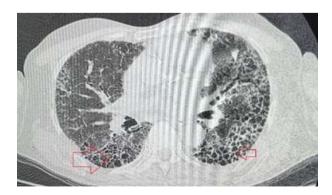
High resolution computed tomography showing UIP pattern (red arrows) of interstitial lung disease.
